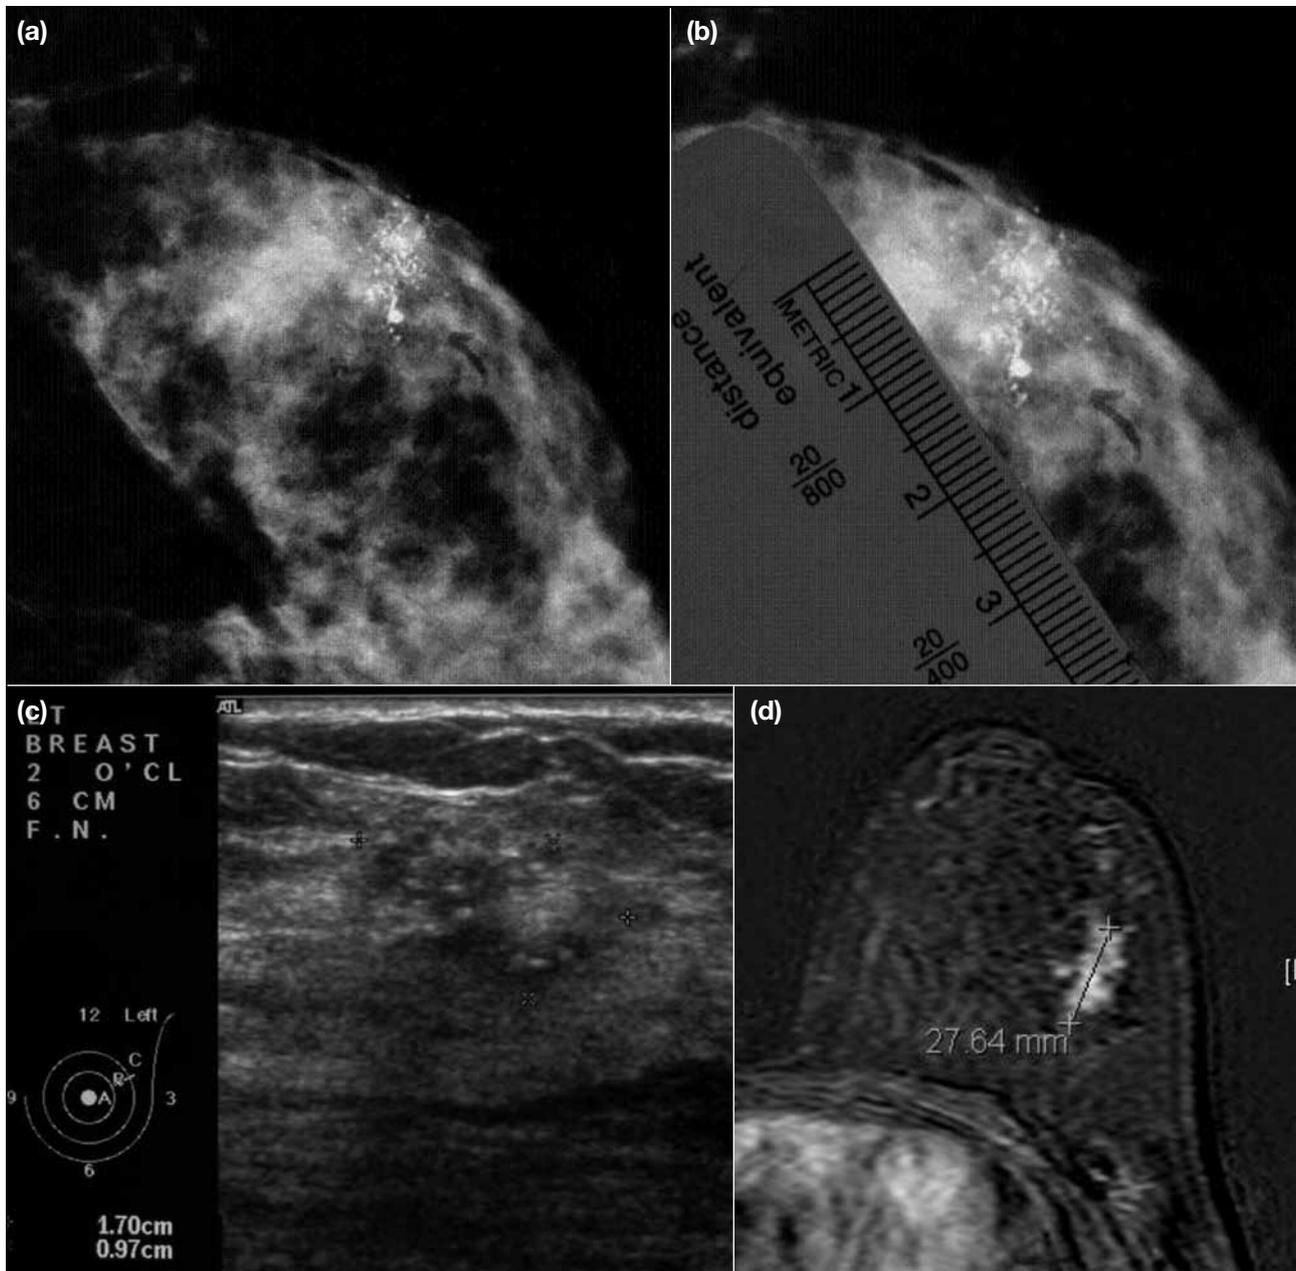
More extensive local disease detected on magnetic resonance imaging (MRI) than mammogram and ultrasound. (a, b) Mammograms (localised cranio-caudal view) show pleomorphic microcalcifications. (c) Ultrasound shows ill-defined heterogeneous mass with microcalcifications. (d) Contrast-enhanced subtracted axial MRI shows ill-defined enhancing lesion, which is larger than that detected in mammogram and ultrasound.
